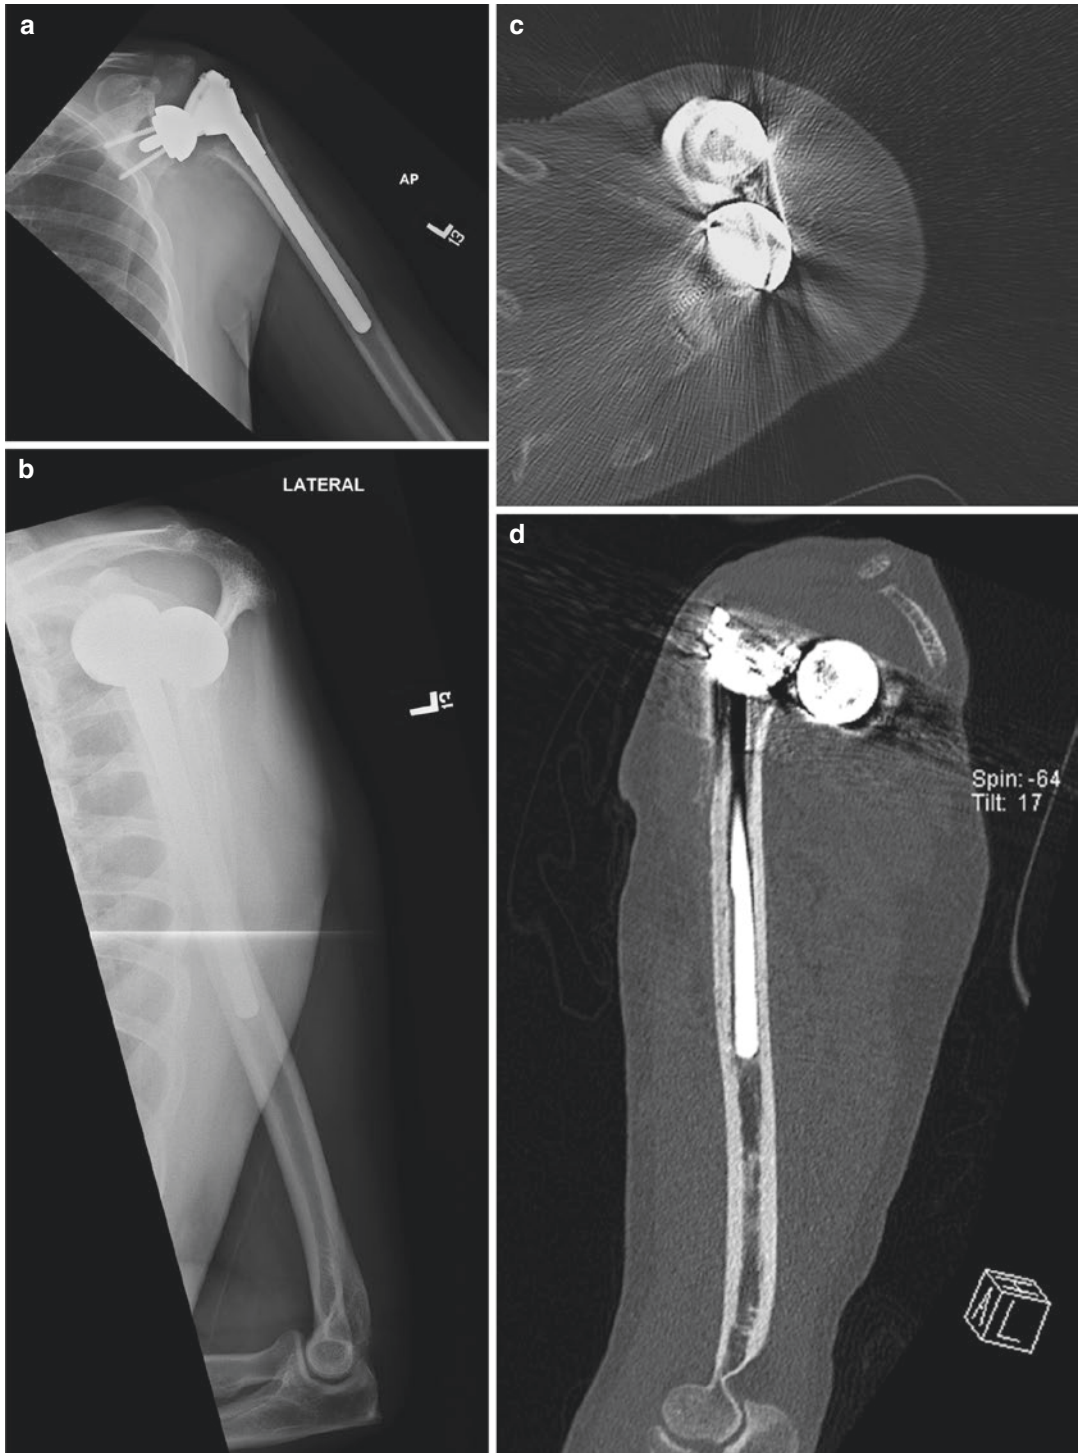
Dislocation. (a) AP and (b) scapular Y view radiographs of a left shoulder RTSA show anterosuperior displacement of the humeral component of a RTSA. (c) Axial and (d) sagittal CT images confirm anterosuperior position
